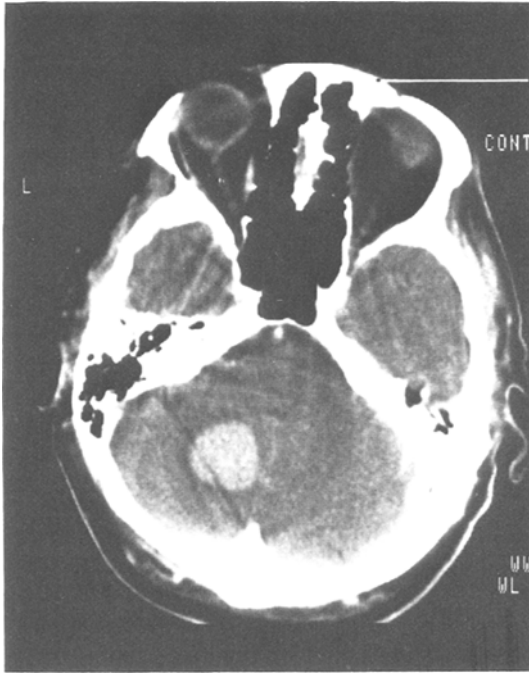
Case 2*: CT scan on admission. Large vermian and left hemispheric haemorrhage in the cerebellum
